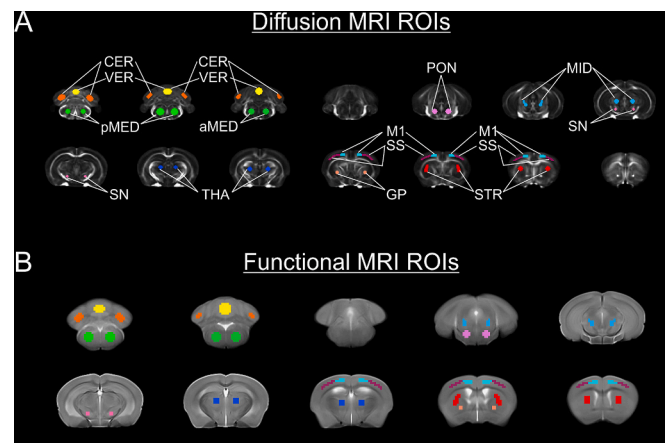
Regions of Interest. The top panel (A) shows diffusion MRI regions of interest overlaid on top of the fractional anisotropy template image: cerebellum (CER; orange), vermis (VER; yellow), posterior medulla (pMED; light green), anterior medulla (aMED; dark green), pons (PON; pink), midbrain (MID; turquoise), substantia nigra (SN; magenta), thalamus (THA; dark blue), globus pallidus (GP; orange), somatosensory cortex (SS; purple), primary motor cortex (M1; light blue), and striatum (STR; red). (For interpretation of the references to colour in this figure legend, the reader is referred to the web version of this article.)
